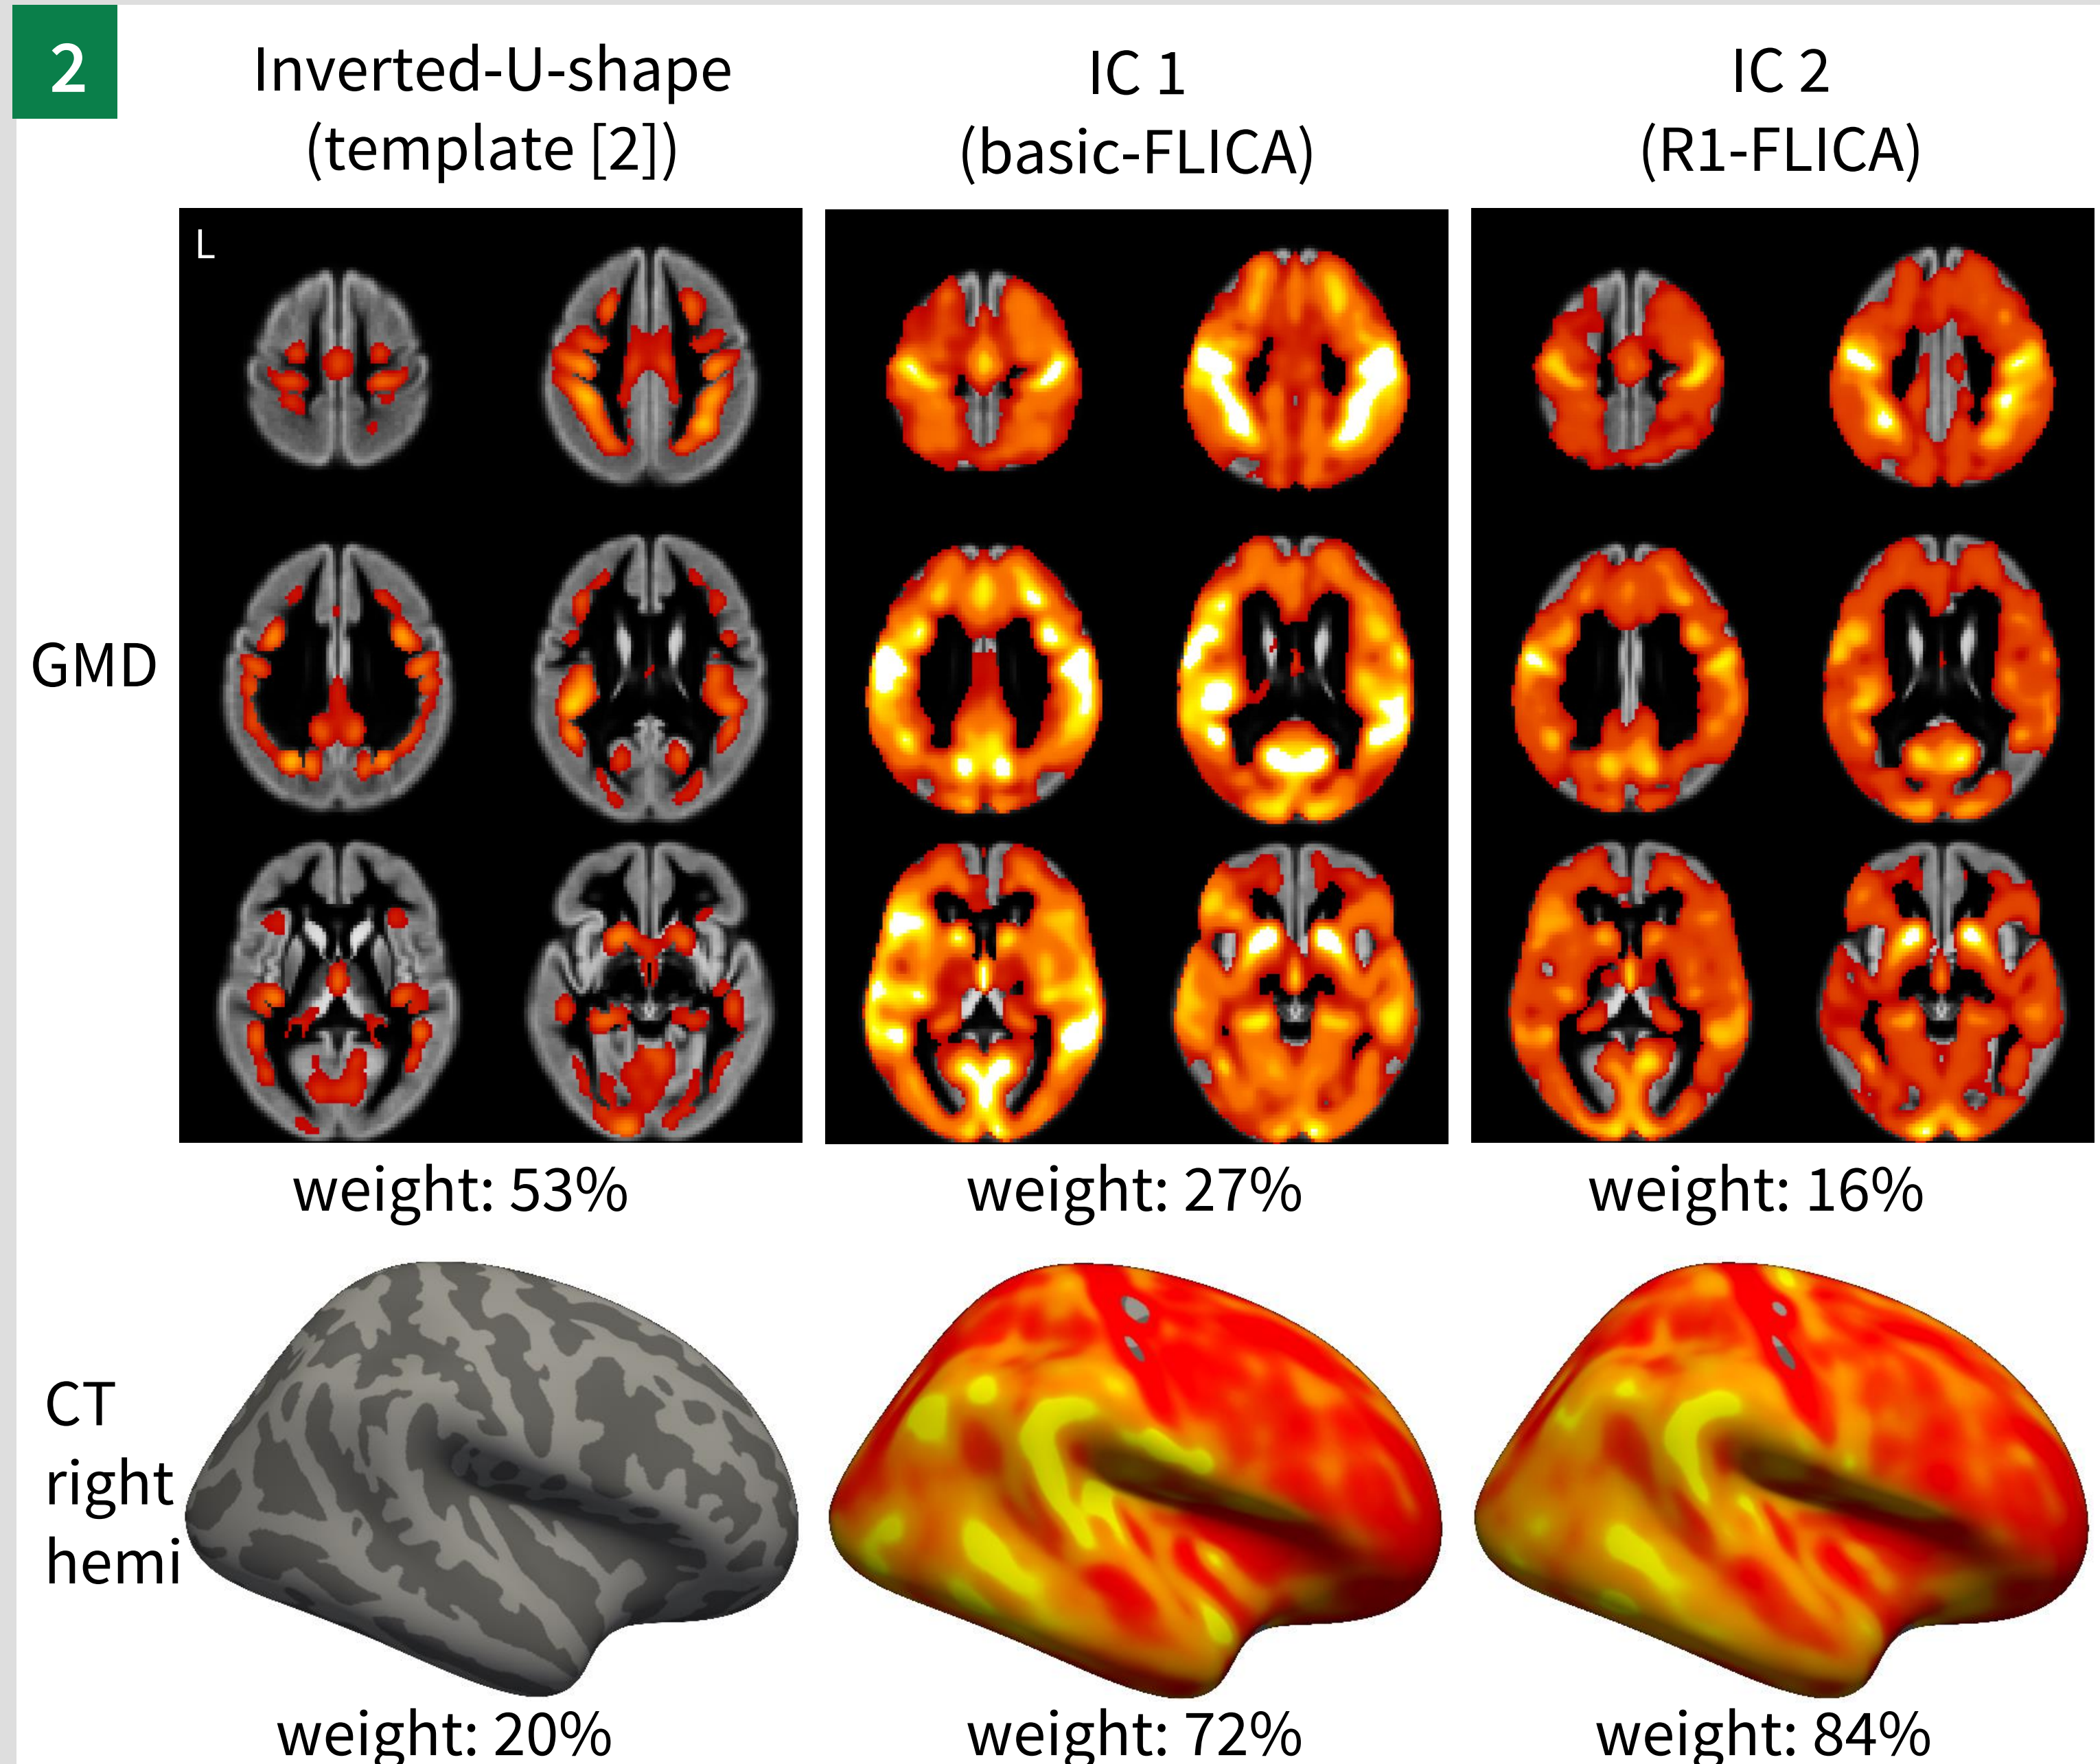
GMD and right hemisphere CT maps from (A) inverted-U-shape network from [2] (B) IC1 from basic-FLICA and (C) IC2 from R1-FLICA. GMD/CT: Z-scale: 3 – 15
